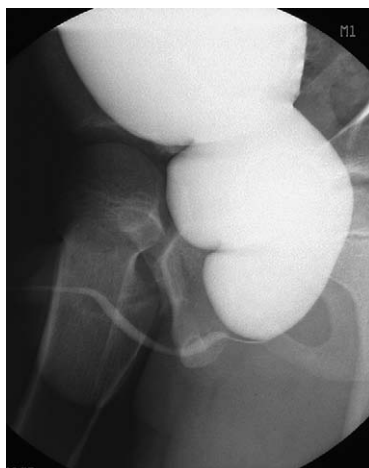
This voiding cystourethrogram demonstrates a dilated posterior urethra secondary to posterior urethral valves in an 8-year-old boy who was screened with a renal/bladder ultrasound.
